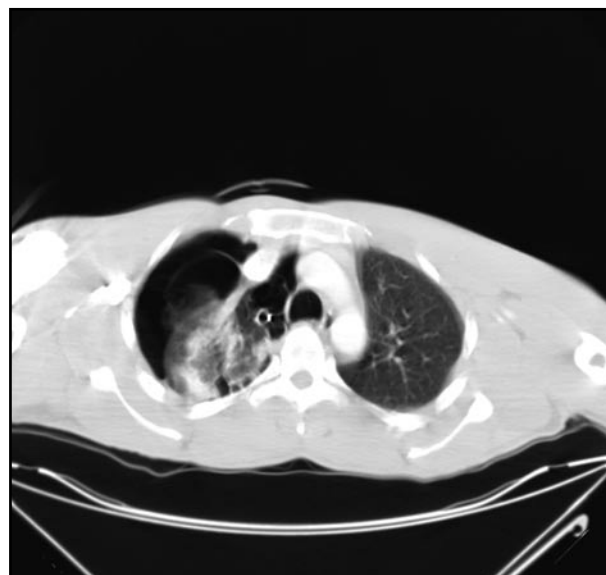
CT scan of the chest showing pneumothorax on the right side with bulla in the apex of right upper lobe
